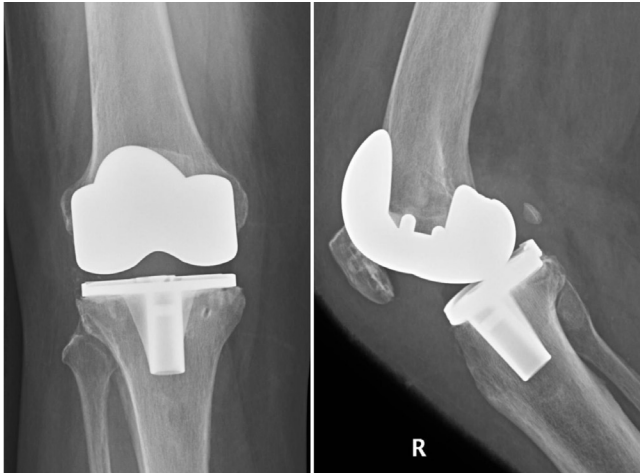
(a) Anteroposterior and (b) lateral radiograph showing the knee after TKA.
